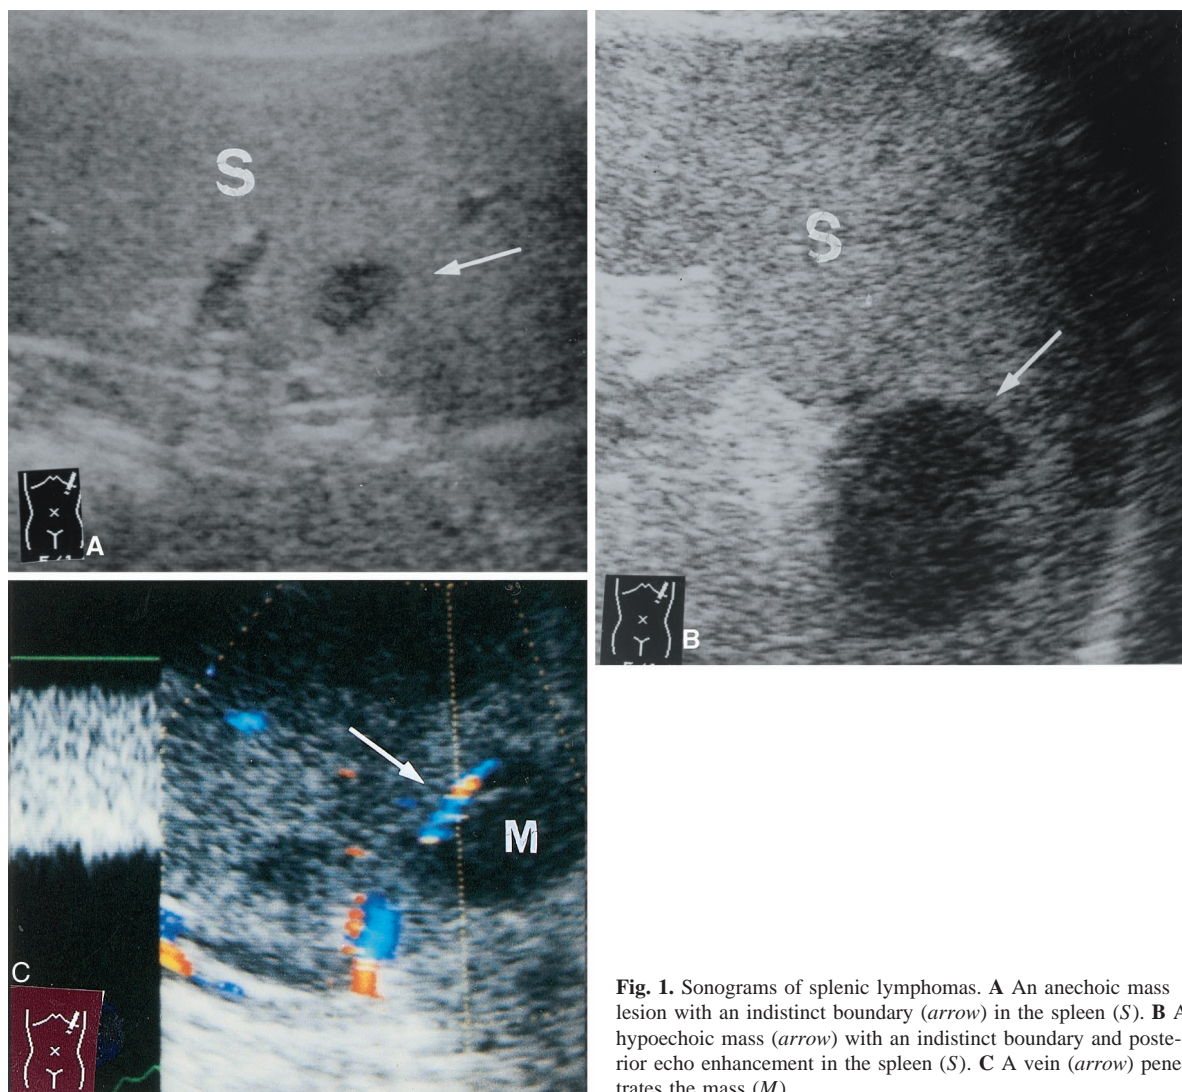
Sonograms of splenic lymphomas. A An anechoic mass lesion with an indistinct boundary (*arrow*) in the spleen (*S*). B A hypoechoic mass (*arrow*) with an indistinct boundary and posterior echo enhancement in the spleen (*S*). C A vein (*arrow*) penetrates the mass (*M*).
